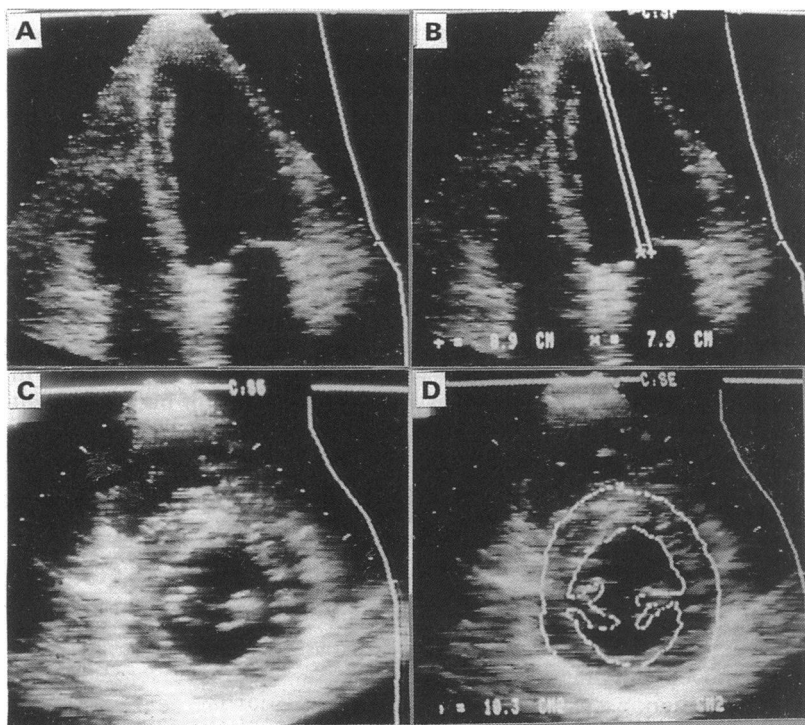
Cross sectional technique for the determination of left ventricular mass. (A) Apical four chamber view, (B) length of left ventricle from mitral annulus to epicardial and endocardial borders, (C) parasternal short axis view, (D) epicardial and endocardial areas measured by planimetry. See text for method of calculation.
